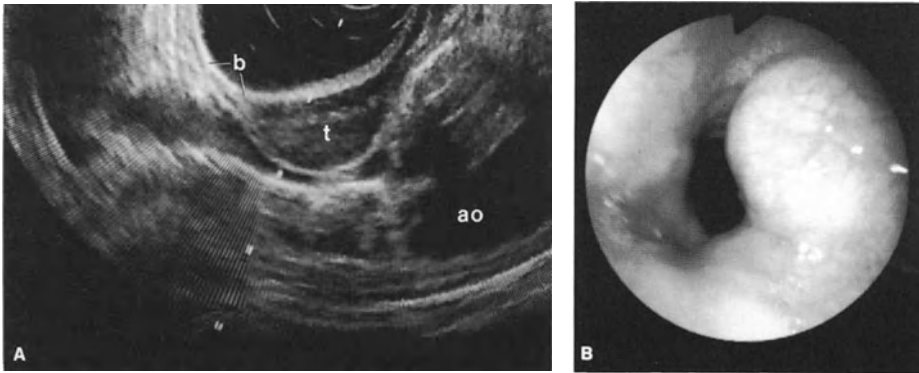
A Endoscopic sonogram showing an ellipsoid, homogeneous hypoechoic echo pattern with sharply delineated borders (*t*) below normal mucosa adjacent to the descending aorta (*ao*). *b*, water-filled balloon. B Corresponding endoscopic image showing bulging of the esophageal wall covered with normal mucosa
